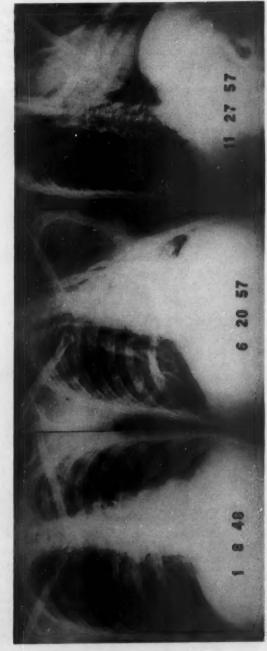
Case 2. White male, age 36, who had had tuberculosis since 1947, when a right pneumothorax was induced. This was continued for two years. A left thoracoplasty was performed in 1949. A left phrenic paralysis was done in 1956. In spite of these measures and multiple courses of antimicrobial therapy over the 10-year period, his sputum remained persistently positive and his tubercle bacilli became resistant to SM and INH. A left pneumonectomy was performed and a "destroyed lung" found containing an irregular 15 mm. cavity, brondinar dilatation and thickening, multiple areas of nodular tuberculosis. (left) Roentgenogram in 1948, showing the right pneumonectory areas of cavitation at left apex. (center) Roentgenogram showing residual fibrotic disease on right and thoracoplasty on left (right) Bronchogram showing dilated bronchial tree on left beneath thoracoplasty.
